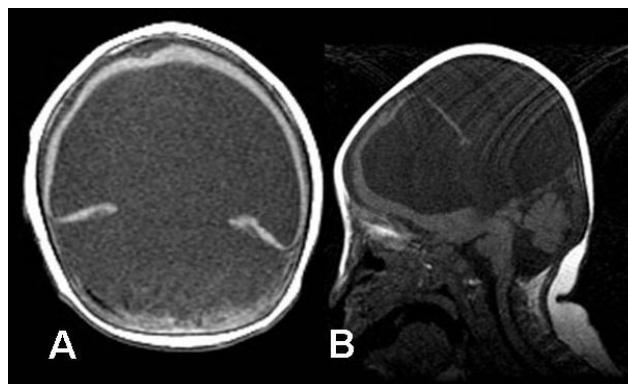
The axial T1-weighted axial (A) and sagittal images (B) showed a "pancake" hemisphere and mono-ventricle.
